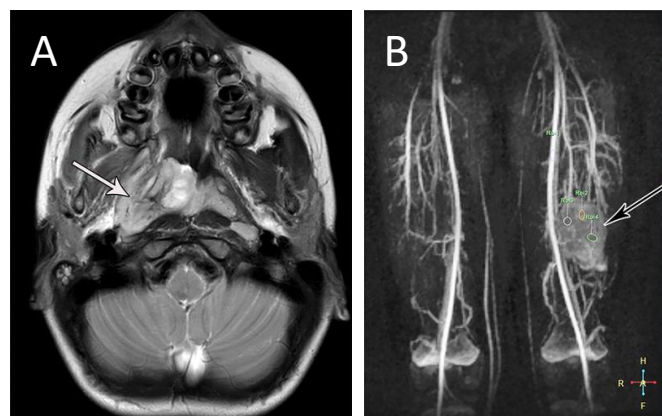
Characteristic MRI images of RMS. A) Axial T2-weighted MRI image of an ERMS involving the parapharyngeal space in a 7-year-old boy in which the tumor mass and its relationship with the adjacent tissues are distinguished. Of note, T1 images optimally show normal anatomy of soft tissue and fat, while T2 images optimally show fluid and alterations (e.g., tumors, inflammation, trauma). B) Alveolar rhabdomyosarcoma in an 11-year-old boy with a left thigh mass. Dynamic contrast-enhanced MRI image shows diffuse early enhancement of the tumor (black arrow). Note that dynamic contrast enhanced (DCE) imaging measures T1 changes in tissues over time after bolus administration of contrast medium (which is frequently gadolinium). Images taken from reference [13].
